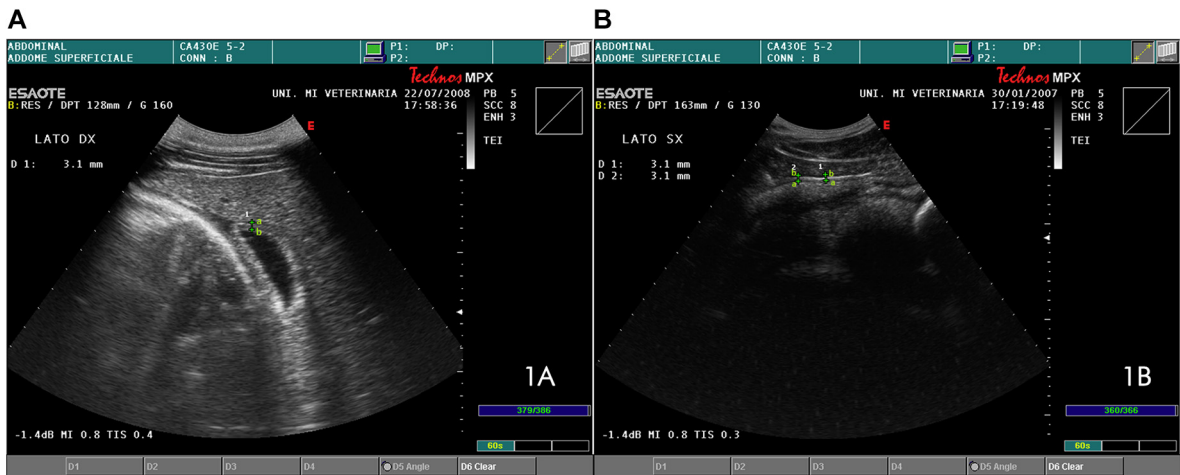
Ultrasonographic measurement of small intestinal wall thickness. Transverse plane (A) of the duodenum and longitudinal plane (B) of a jejunal loop visualized transabdominally using a 3.5 MHz convex transducer; the measurements were taken from the hyperechoic serosa layer to the inner hyperechoic mucosal surface.
